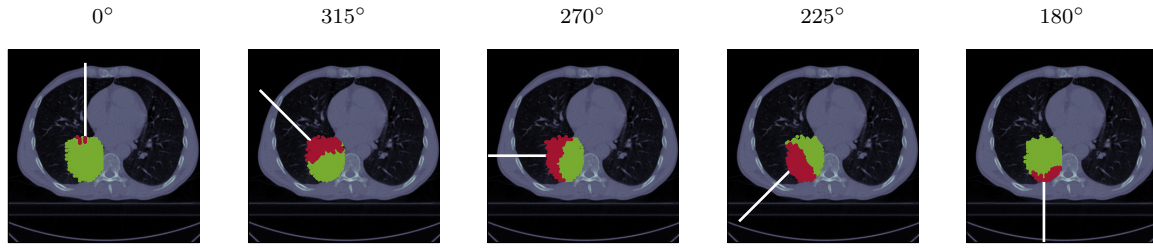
Axial CT slice for patient No.114 with different beam angles. The overlay highlights the spots in green (●) with sufficiently large residual helium range and the ones with insufficient residual helium range in red (●).
